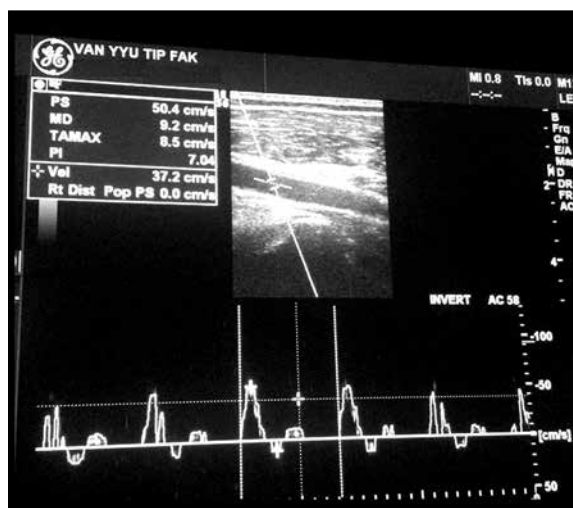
Duplex doppler sonographic image of the popliteal artery demonstrating pulsatility index, as described in the materials and methods section.
